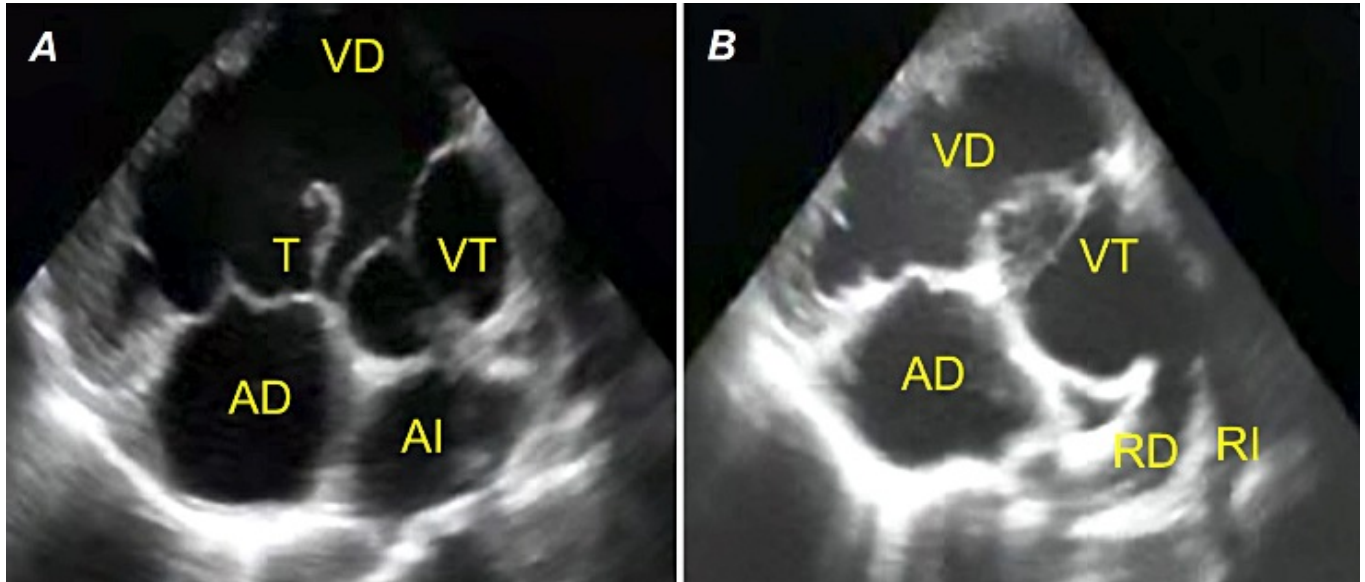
A. High parasternal short axis view, where the truncal vessel is seen, as well as dilated right ventricle and accessory tricuspid tissue. B. Persistent truncus arteriosus, type I. Acronyms in Spanish - AD: right atrium, AI: left atrium, RD: right pulmonary artery, RI: left pulmonary artery, T: accessory tricuspid tissue, VD: right ventricle, VT: truncal vessel.
